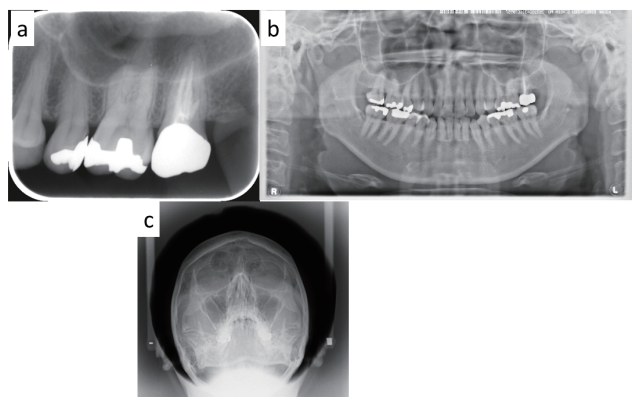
(a) Periapical and (b) panoramic radiographs showing radiolucent areas in the maxillary left second molar. (c) A Waters radiograph did not show any abnormal findings in the teeth or maxillary sinuses. Radiolucent areas in the maxillary left second molar disappeared 1 year after the root canal treatment.
